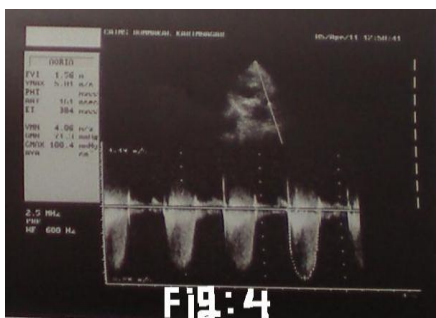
Continuous wave doppler at pulmonary valve show severe pulmonary stenosis.
